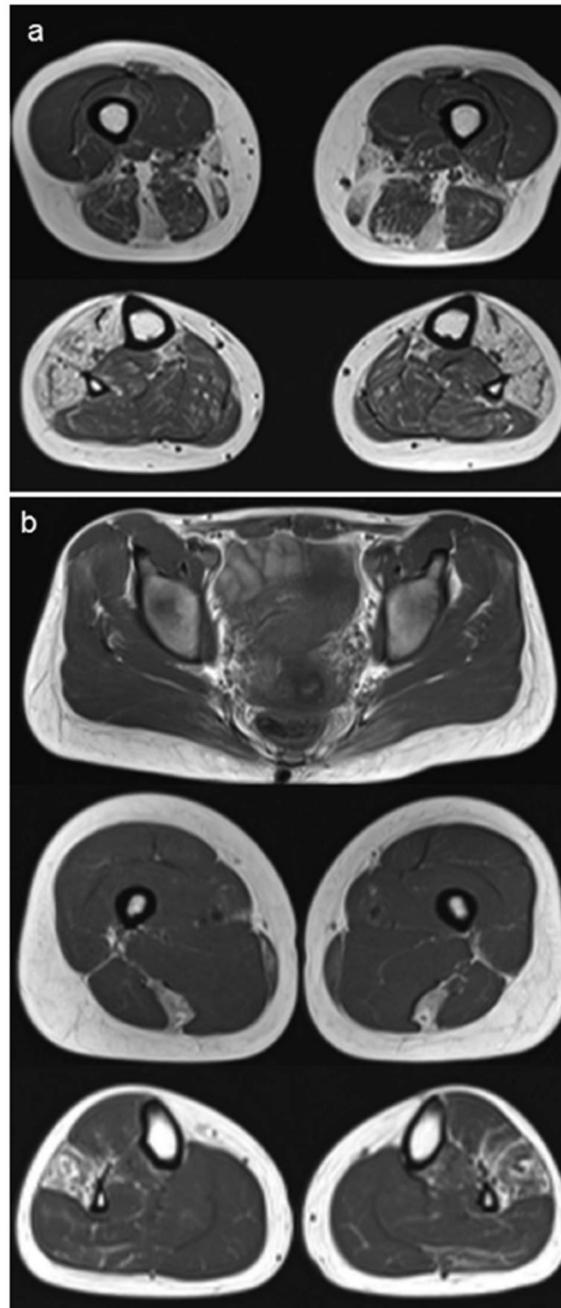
Muscle MRI findings
